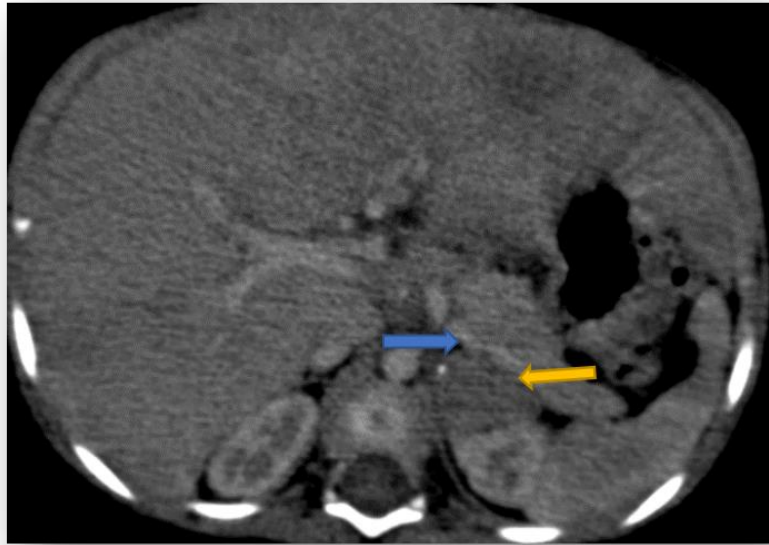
Axial CT image showing well-defined, smooth-contoured mass of the left adrenal fossa, hypodense on unenhanced CT (yellow arrow), exhibiting a few peripheral calcifications (blue arrow)
